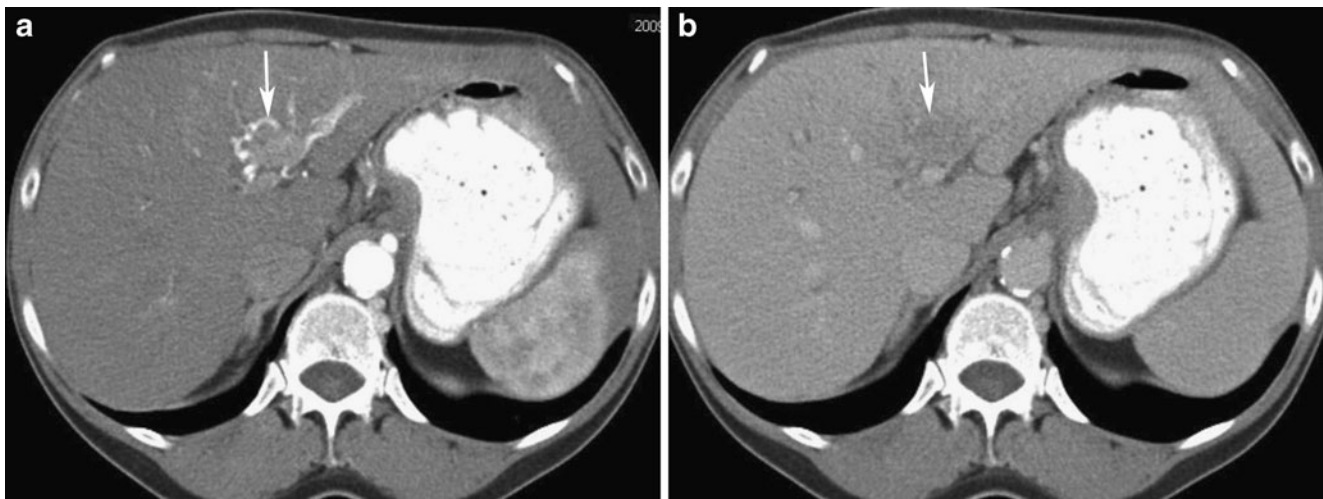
Sixty-six-year-old man with infiltrative hepatocellular carcinoma. a Axial contrast-enhanced CT in the arterial phase shows early enhancement or “arterializations” of the left portal vein (*arrow*)
